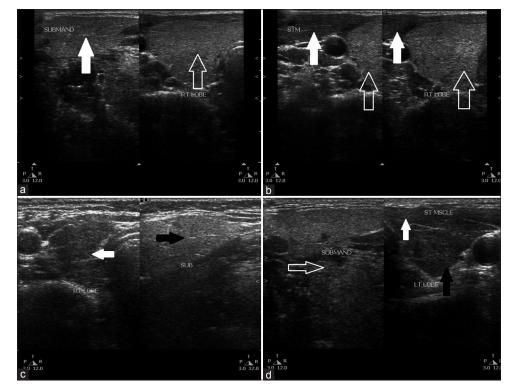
(a) Ultrasonography showing hyperechoic right lobe of thyroid (hollow white arrow) as compared to submandibular gland (solid white arrow) (normal, Grade-1). (b) Ultrasonography showing hyperechoic right lobe of thyroid (hollow white arrows) as compared to prethyroid muscles (solid white arrows) (normal, Grade-1). (c) Ultrasonography showing hypoechoic right lobe of thyroid (white arrow) as compared to submandibular gland (black arrow) (mild AITD, Grade-2). (d) Ultrasonography showing hypoechoic left lobe of thyroid (black arrow) as compared to both submandibular gland (hollow white arrow) and prethyroid muscles (solid white arrow) (moderate AITD, Grade-3). AITD: Autoimmune thyroid disease
